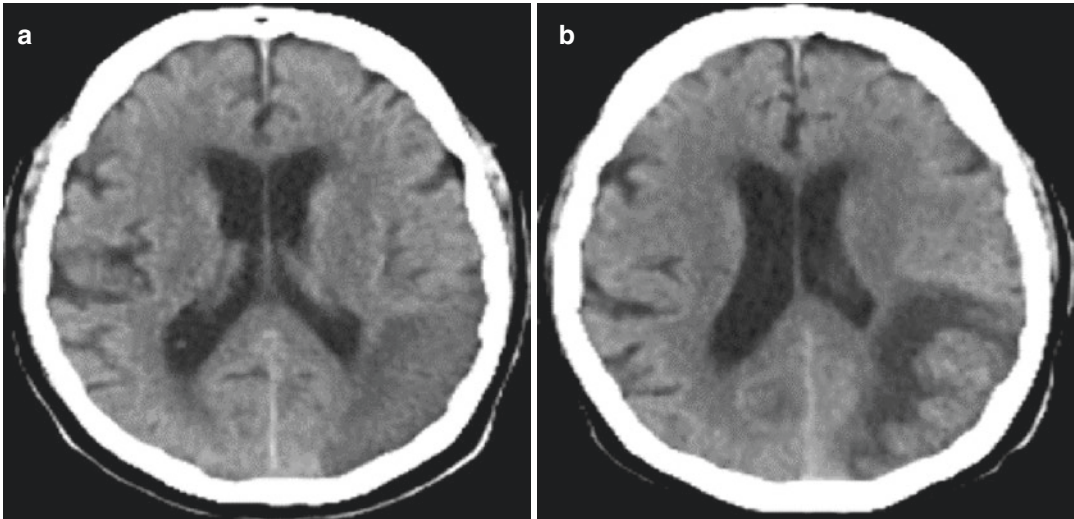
(a) Noncontrast CT shows acute infarction at the posterior temporal lobe. (b) 3 days later, hyperdense areas consistent with hemorrhage occurred in the infarcted area. Hemorrhagic transformation
